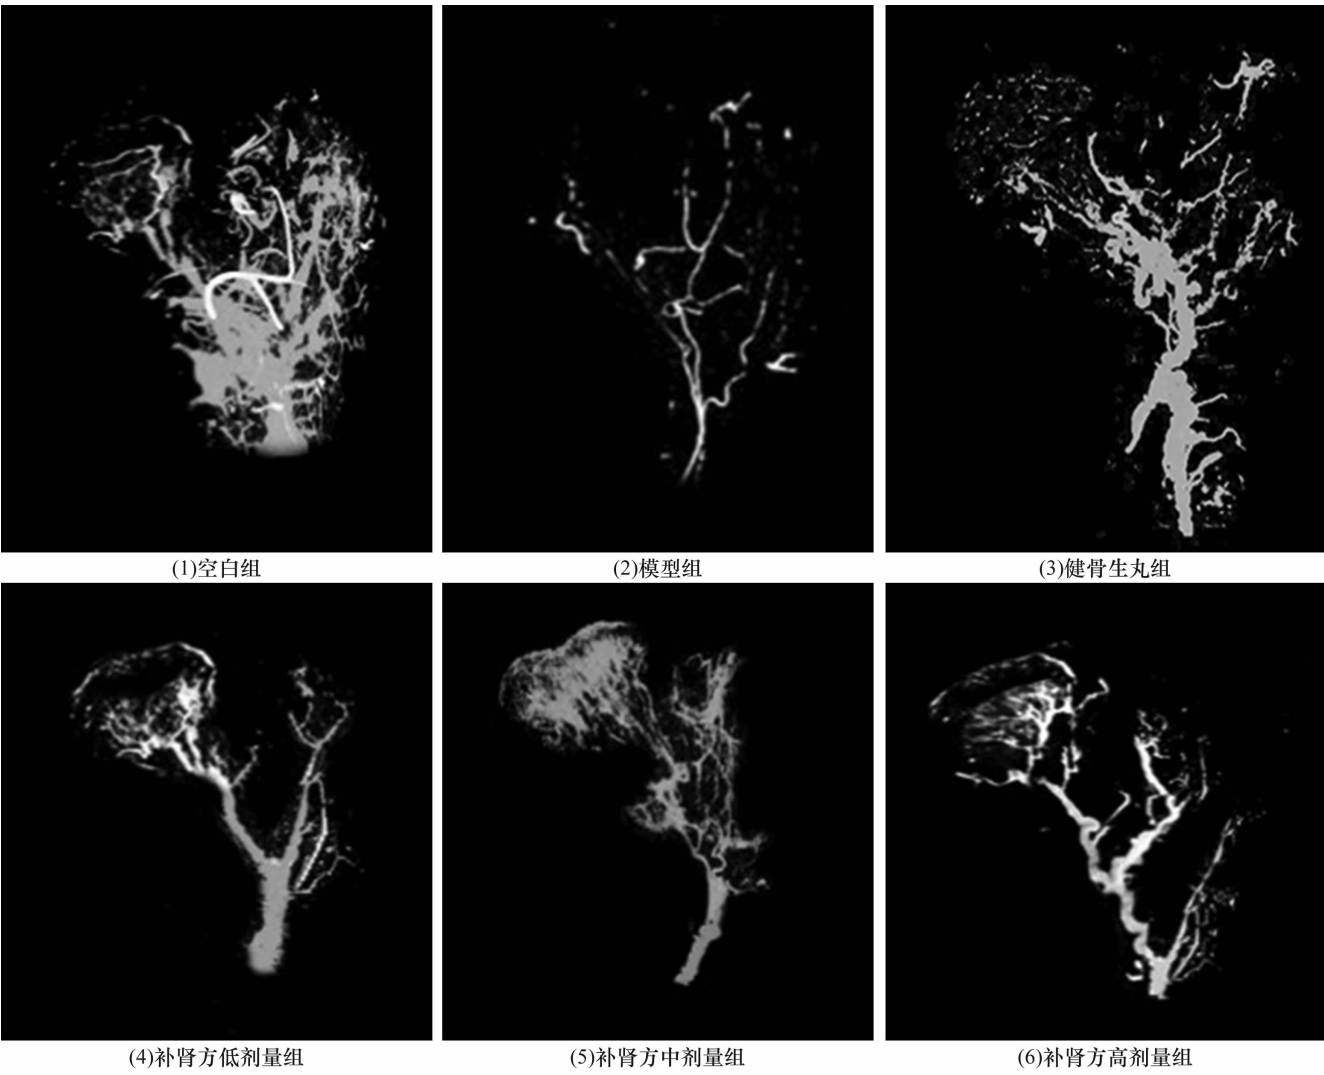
6 组大鼠股骨头血管 Micro - CT 检查结果
